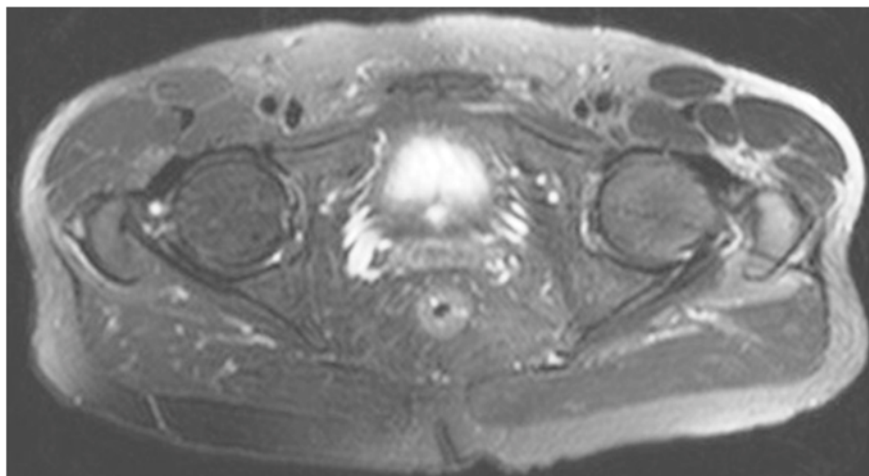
Suboptimal but still readable axial intermediate-weighted fat-suppressed MRI of the pelvis with inhomogeneous fat suppression.
